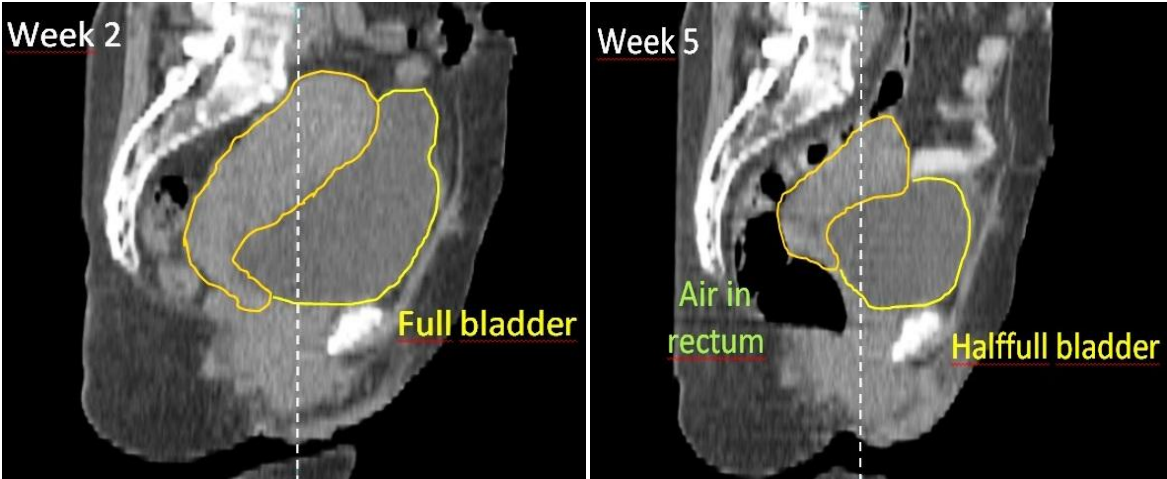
Sagittal view of variable bladder and rectum filling CT-scans in week 2 and week 5 during treatment course, respectively for cervix-uterus cancer patient. The influence of variable bladder and rectum filling can be seen in the change of cervix-uterus position. The above shown images are taken from (31)
